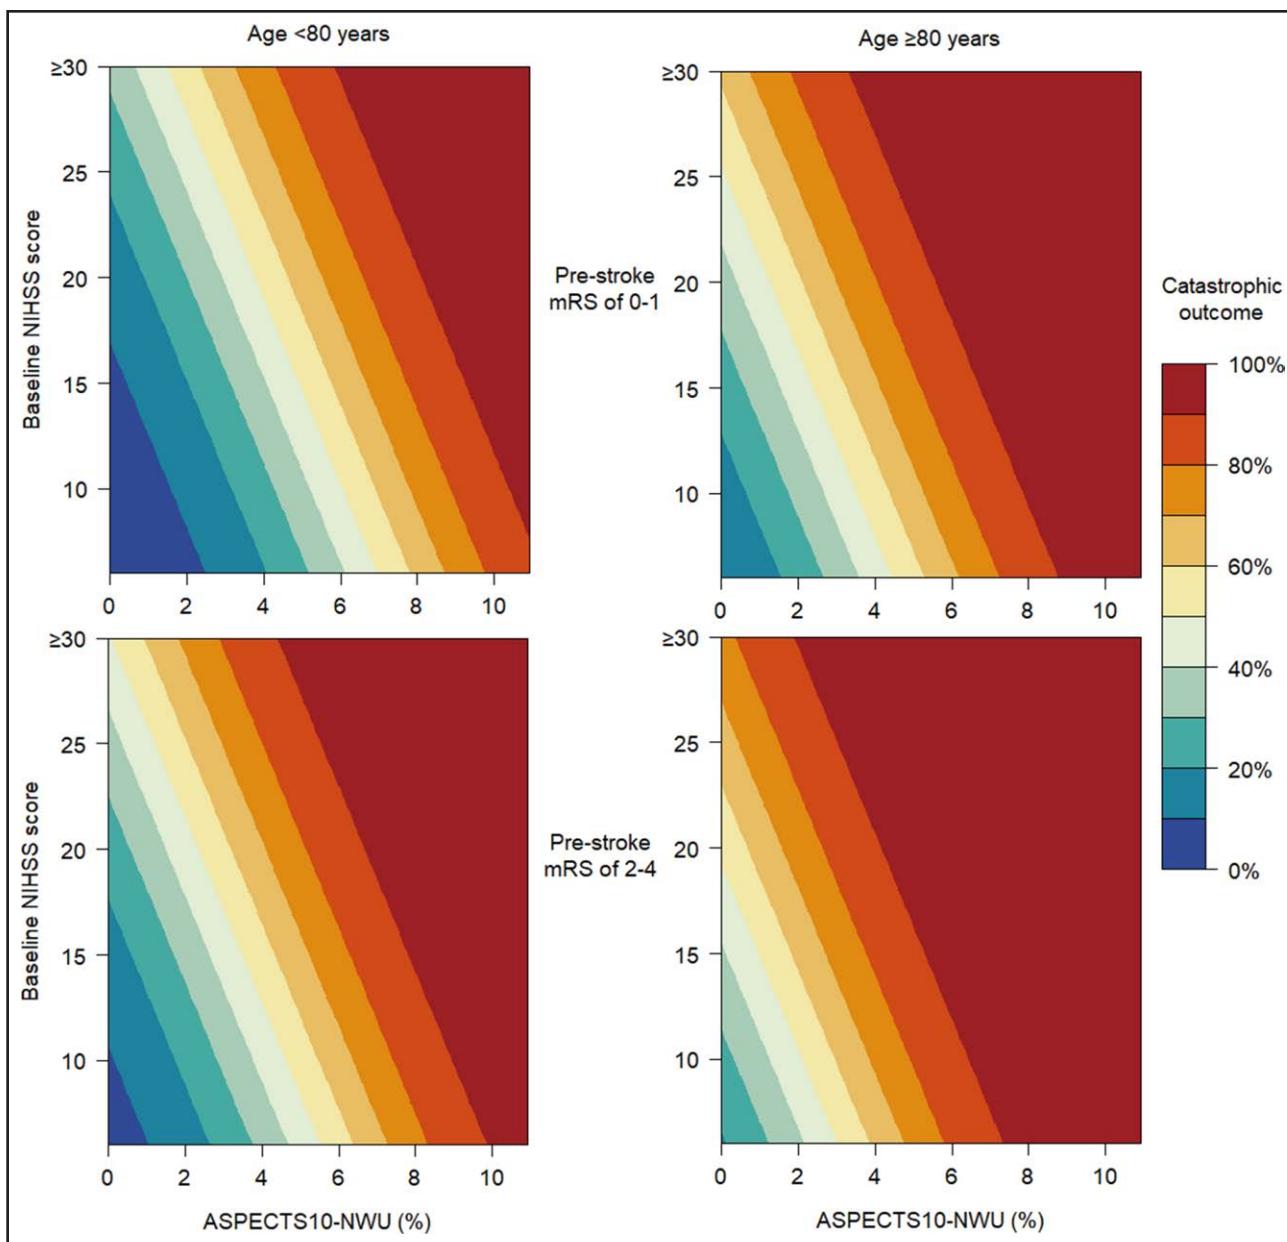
Predicted probability for 3-month catastrophic functional outcome (modified Rankin Scale [mRS] score, 5 or 6) associated with Alberta Stroke Program Early Computed Tomography Score (ASPECTS) 10-net water uptake (NWU), age, prestroke mRS score, and baseline National Institutes of Health Stroke Scale (NIHSS) score in patients with acute ischemic stroke with ASPECTS ≤5 treated with endovascular thrombectomy.
